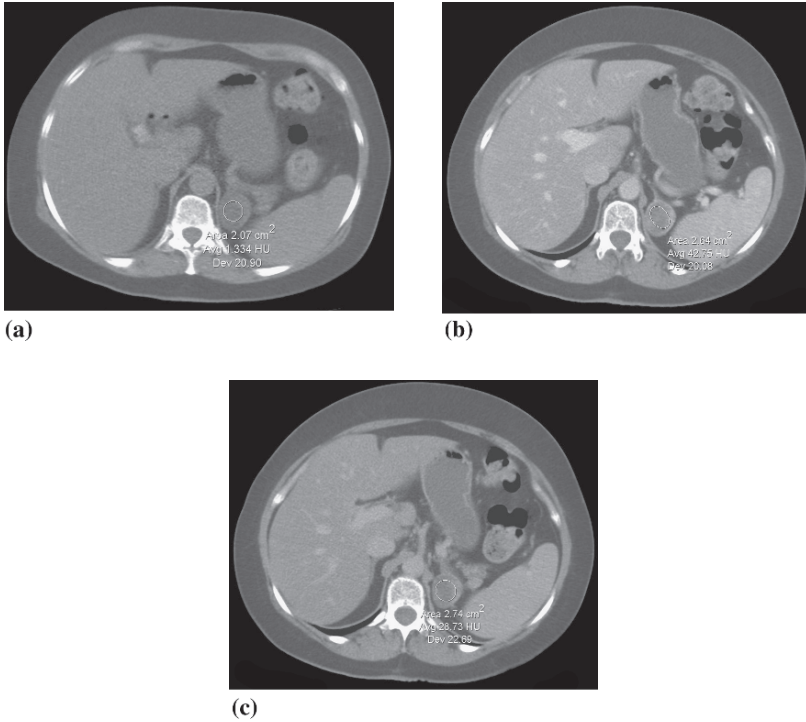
Adrenal adenoma on CT. Large left adrenal mass measuring 1 HU pre-contrast (a), 43HU on dynamic imaging (b) and 29HU on 10-minute delayed imaging (c). The low pre-contrast attenuation of the lesion <10HU is consistent with a lipid rich adenoma although the washout values are not very high
